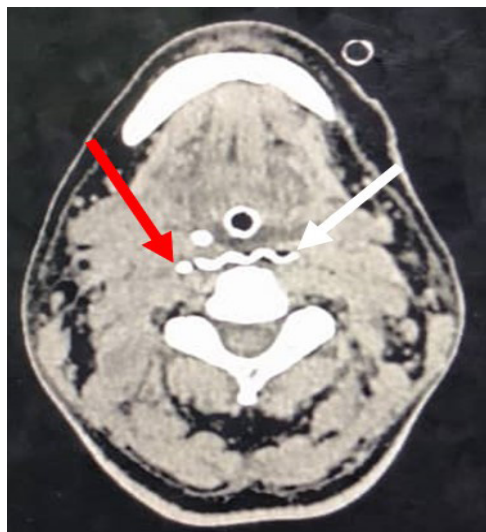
A repeated CT neck on postoperative day 4 showed a linear hyperdense foreign body (indicated by a red arrow) at the C2/C3 level, located just lateral to the corrugated drain (white arrow)
